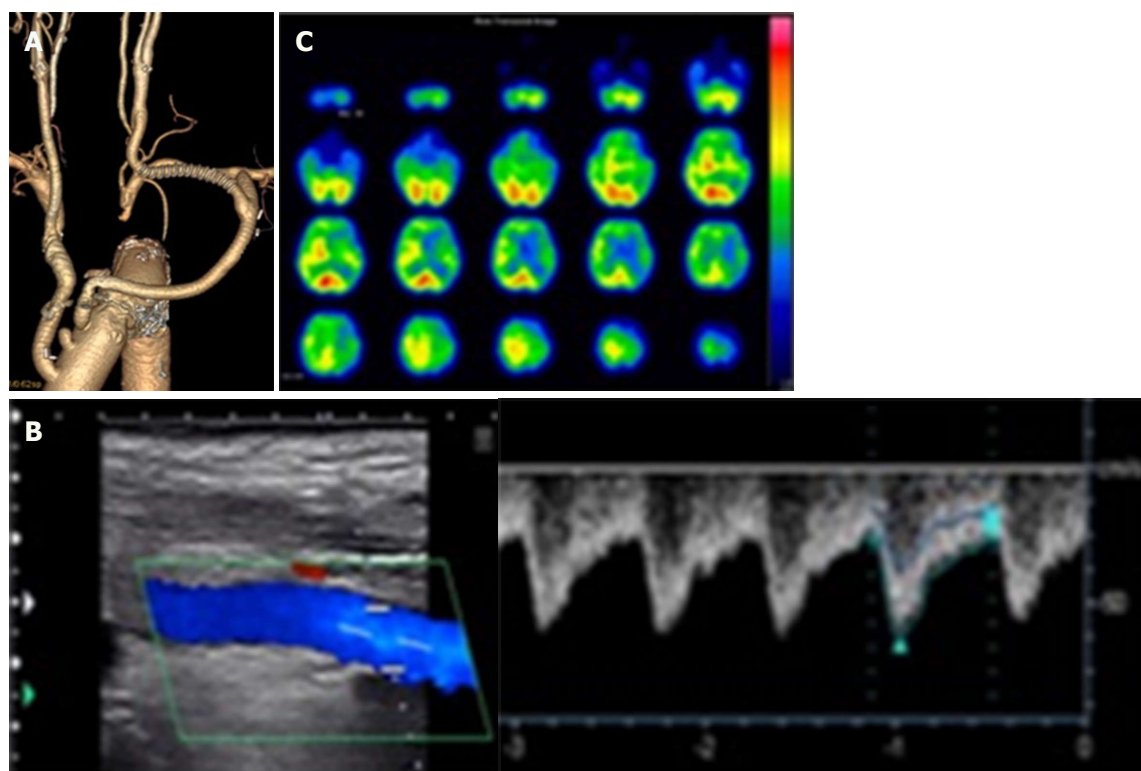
The findings of enhanced computed tomography, color duplex sonography and single-photon emission computed tomography after bypass. A: Enhanced computed tomography findings. After the bypass procedure, the inflow is through the subclavian artery and the outflow is through the distal common carotid artery. Bifurcation of the external carotid artery and internal carotid artery is patent; B: Color duplex sonography findings. After bypass, the peak systolic velocity of the internal carotid artery was 60 cm/s; C: Single-photon emission computed tomography findings. After bypass, the cerebral blood flow was 38.39/31.04 mL/min per 100 g. The asymmetry ratio was 81%.
